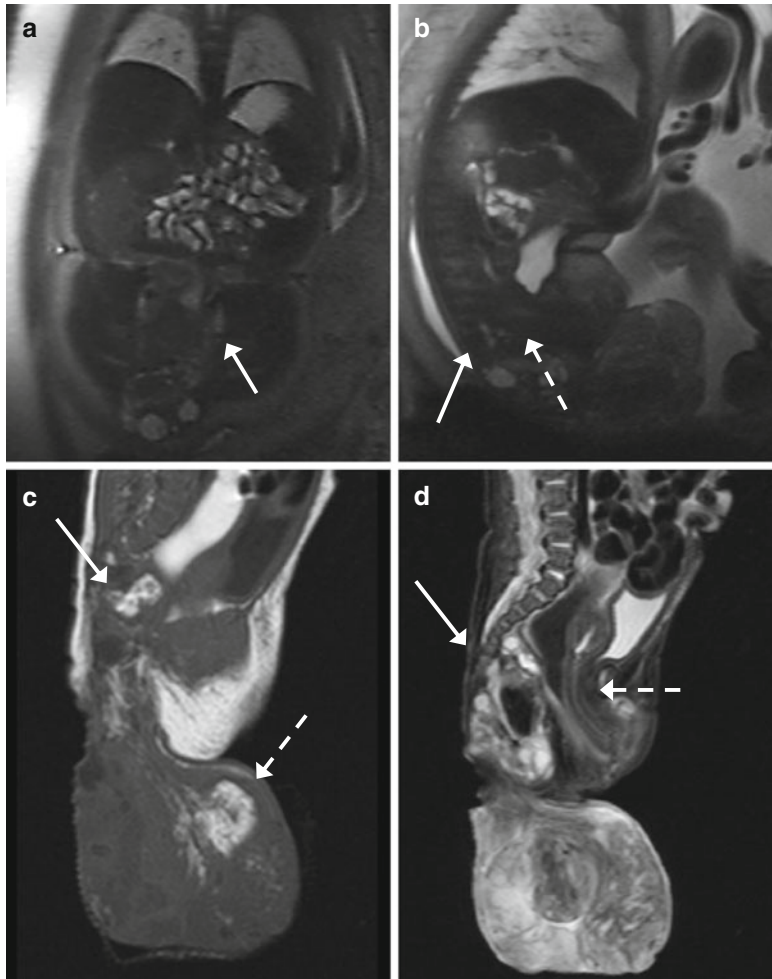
Sacrococcygeal teratoma (GW 37+6). (a, b) Coronal (a) and sagittal (b) T2-weighted images (TR/TE ∞ /95 ms): a sacrococcygeal mass, with an inhomogeneous structure, with solid and with cystic areas, is shown. It has a prevailing exophytic growth but also a significantly intrapelvic portion (arrow, a). There are no signs of communication with the neural tube, which does not show cleft defects (arrow, b). The cleavage plane with the rectus and the bladder is preserved (dashed
